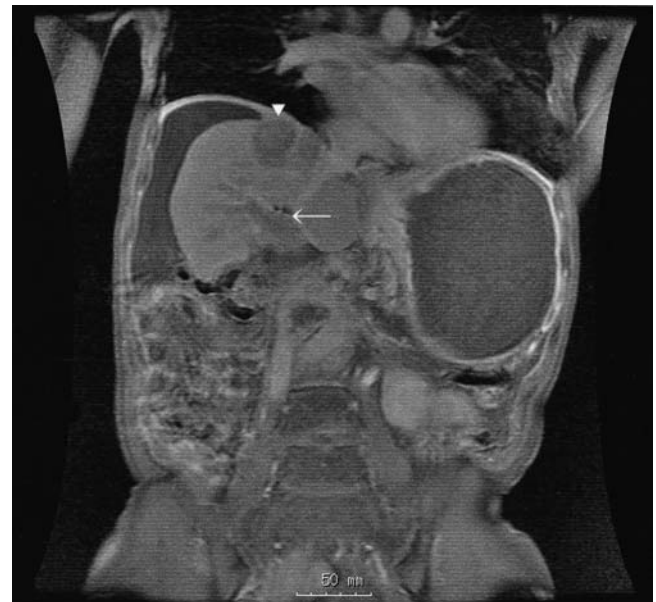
T1-weighted magnetic resonance imaging, on September 2, demonstrated a solid lesion in the portal vein (*arrow*) and the previously treated lesion in the liver (*arrowhead*)
